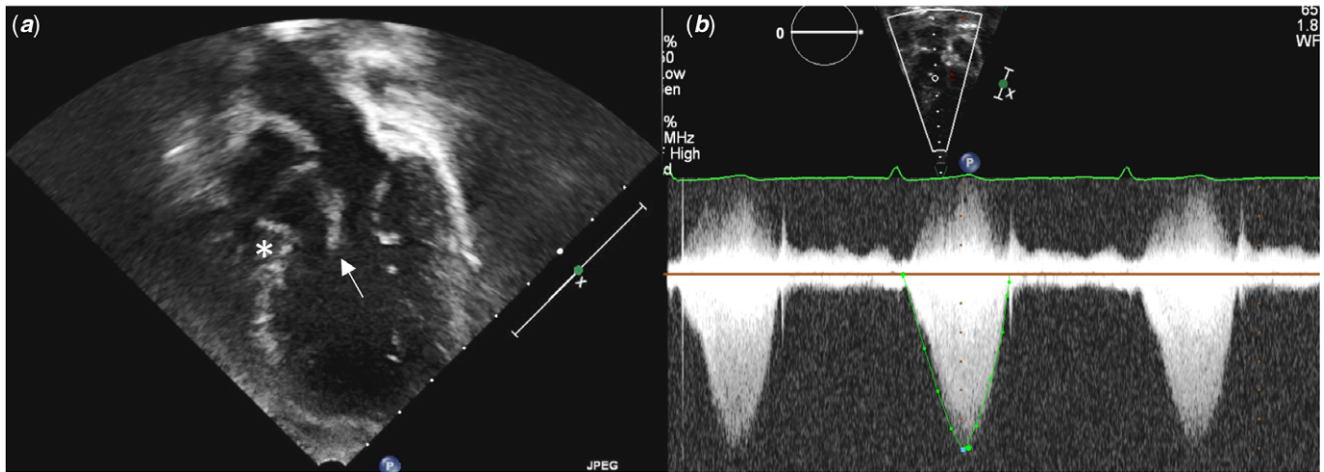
(a) Apical three-chamber view of transthoracic echocardiography during his follow-up. There was a systemic ventricular outflow tract obstruction with a prominent muscle ridge of ventricular septum (*) and chordal attachments from the mitral valve (arrow). (b) Doppler echocardiogram across SVOT. There was a peak pressure gradient of 42 mmHg.
